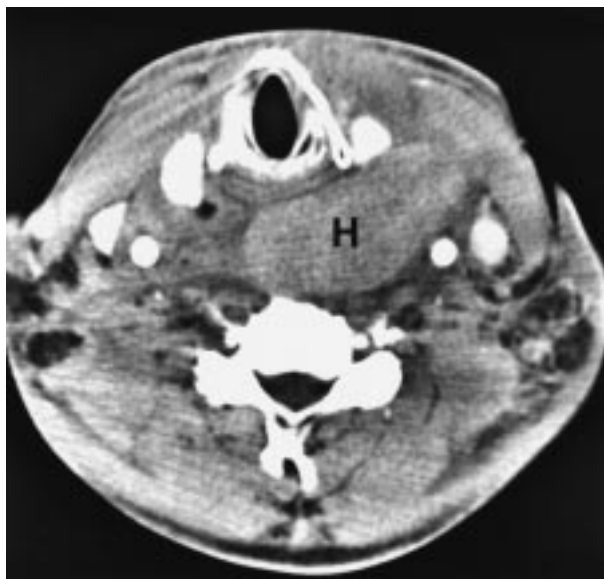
Postoperative CT of the cervical spine shows the prevertebral hematoma (H) compressing the trachea.
